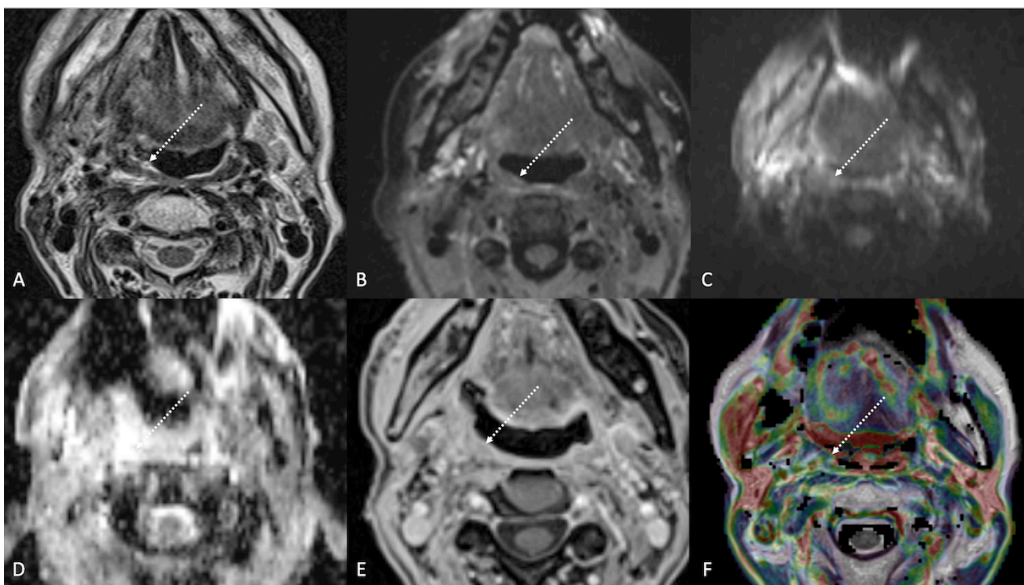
Pre-treatment Magnetic Resonance Imaging (MRI) of a 47-year-old female patient with Human Papilloma Virus negative carcinoma of the left palatine tonsil with buccal space and mandibular invasion, and ipsilateral lymph node metastasis (T4aN1). MR images show an infiltrative tumour arising from the left palatine tonsil that extends into the ipsilateral amigdalo-glossus sulcus, buccal fat space, and mandibular canal (white arrows). The lesion shows hyperintense signal on T2-weighted (a), T2-weighted fat saturated (b), and diffusion weighted  $b_{800}$  images (c) compared to muscle signal, low median apparent diffusion coefficient value ( $0.834 \times 10^{-3} \text{ mm}^2/\text{s}$ ) (d), vivid and inhomogeneous enhancement on T1-weighted image after gadolinium contrast agent injection (e), and high  $K(\text{trans})$  value ( $117,63 \times 10^{-3} \text{ min}$ ) on dynamic contrast enhancement-perfusion weighted imaging (f).
